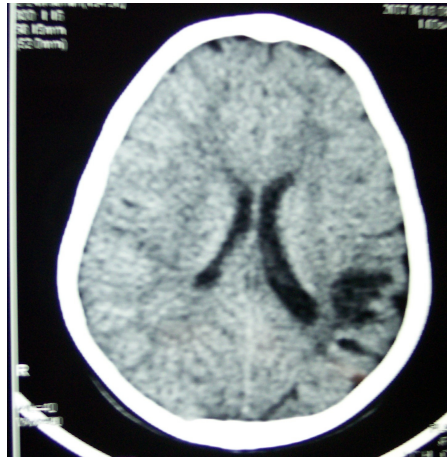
CT picture showing hypodense lesion left occipitoparietal region probably chronic infarct with passive dilatation of occipital horn of left lateral ventricle
